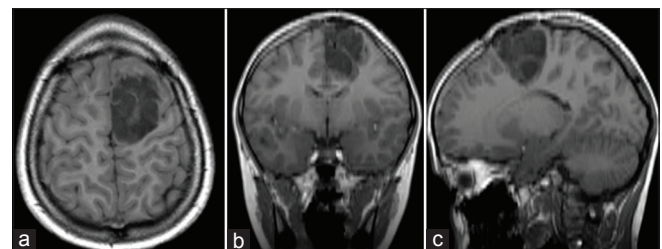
(a-c) Axial, coronal and sagittal 3D T1 FFE MR images of the lesion for preoperative planning in 2002, showing the lesion's inferior extension in the white matter to within a few millimetres of the superolateral edge of the left lateral ventricle
